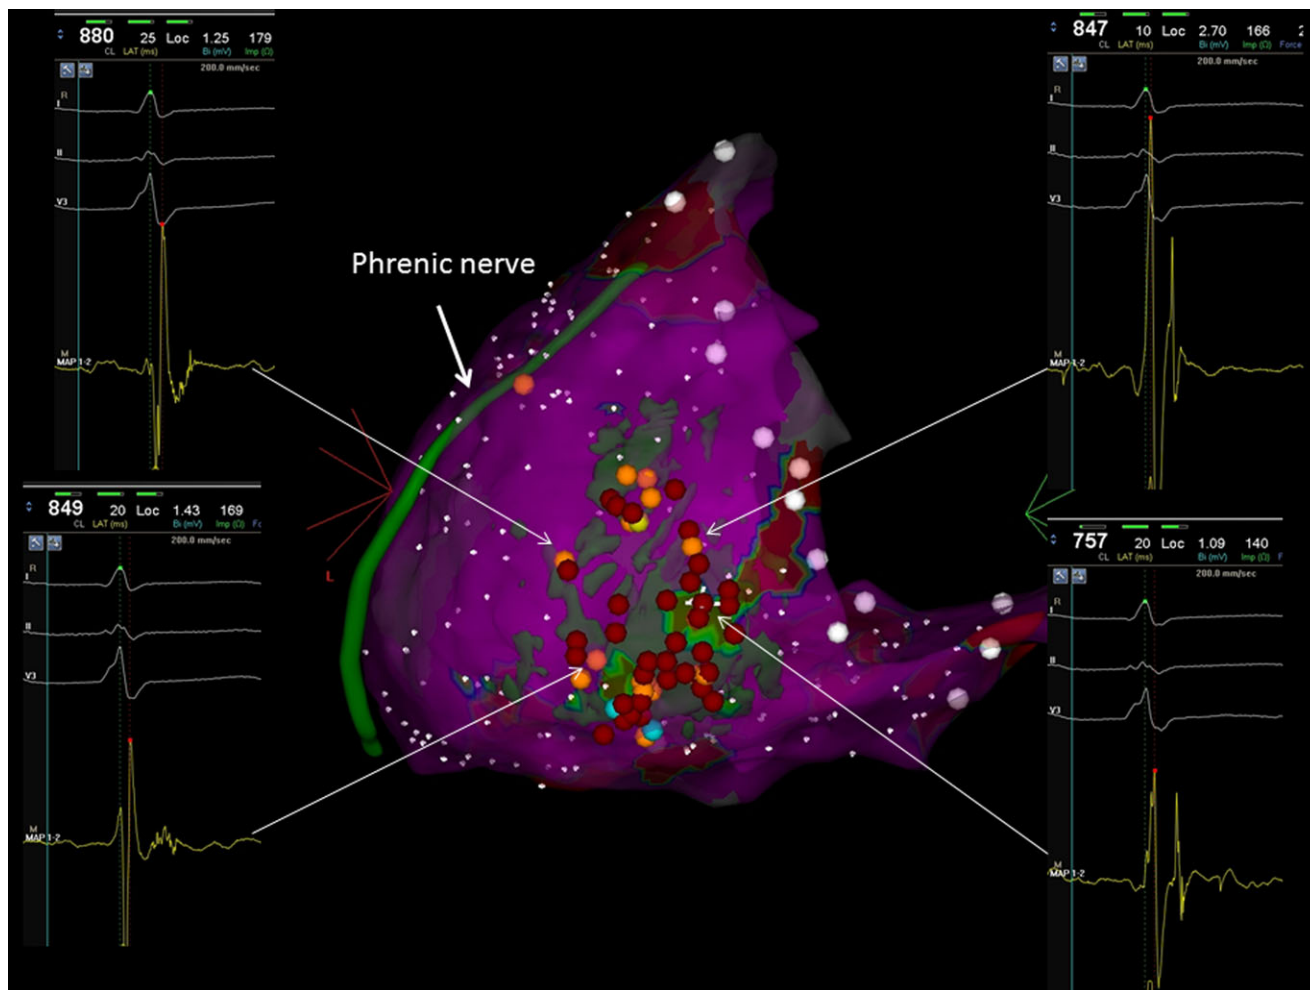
Epicardial voltage map with merged delayed enhancement area in semitransparent green. Early LAVA are typically found in border-zone area. Merged DE-MRI is extremely helpful to focus on area of interest and not forget any area of scar. In this patient, ablation of early LAVA in border zone area allowed us to eliminate LAVA within the center of the scar.
